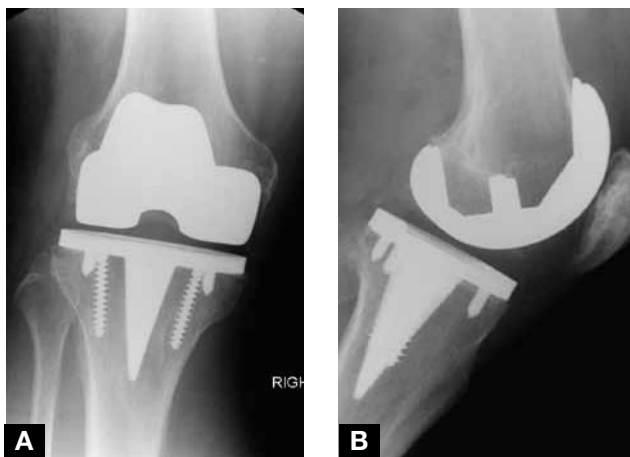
(A, B) At 13 years, radiographs of NK-II system with cementless fixation of femoral component and stemmed tibial baseplate and supplemental screws.
